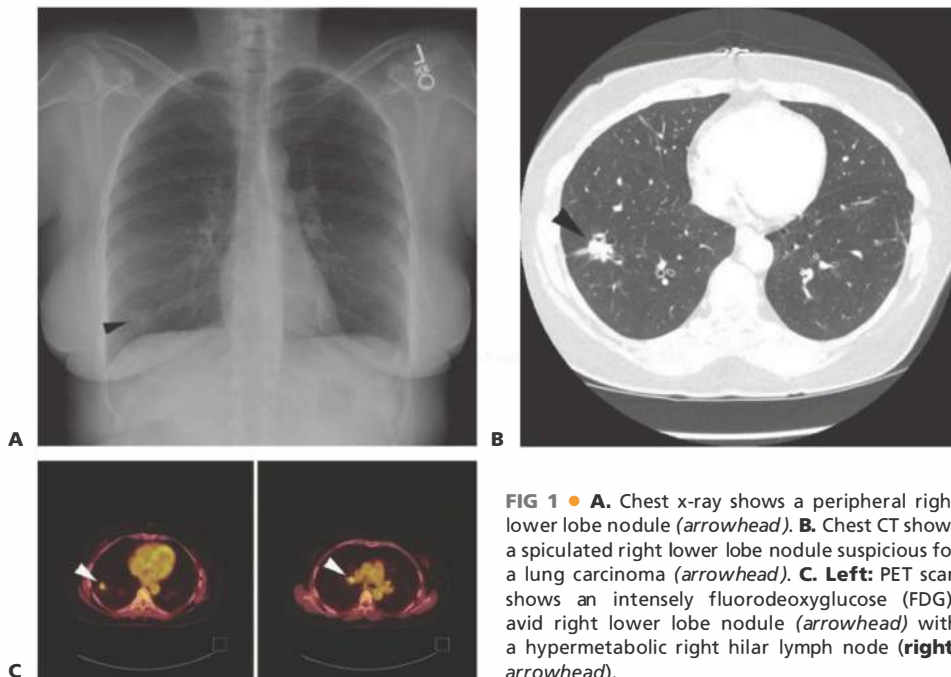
• A. Chest x-ray shows a peripheral right lower lobe nodule (*arrowhead*). B. Chest CT shows a spiculated right lower lobe nodule suspicious for a lung carcinoma (*arrowhead*). C. Left: PET scan shows an intensely fluorodeoxyglucose (FDG)-avid right lower lobe nodule (*arrowhead*) with a hypermetabolic right hilar lymph node (right; arrowhead).
